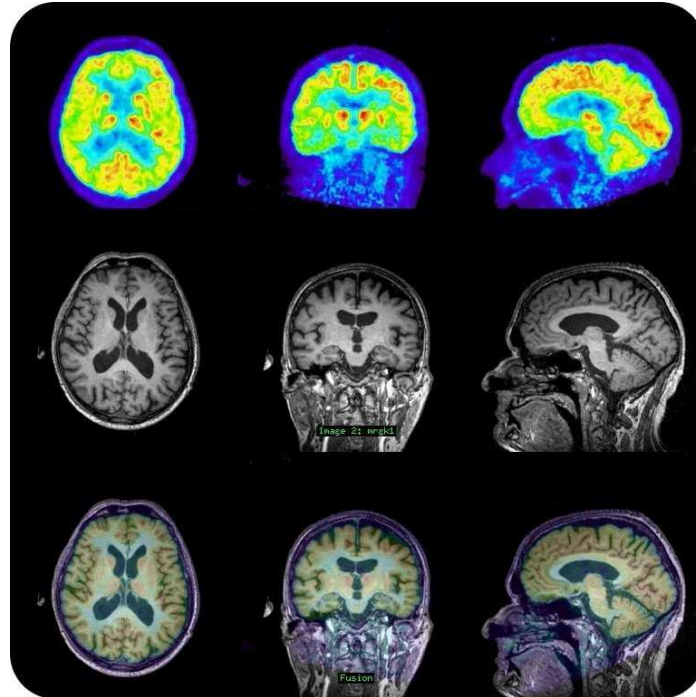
2: Simultaneously measured PET and MR images. First row: [18F]-FDG image. Second row: T1-weighted MR image (MPRAGE). Third row: Fusion of FDG and MPRAGE image. The PET images were reconstructed using the image reconstruction platform PRESTO (Weirich et al. 2010).
